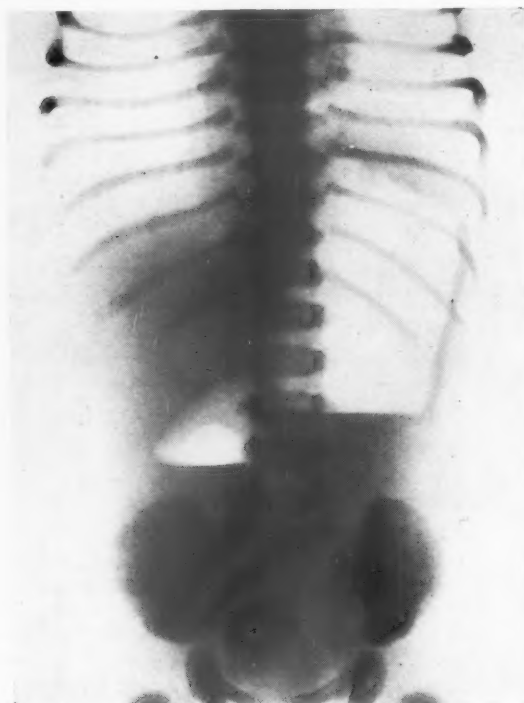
Case 1: radiograph of abdomen (patient sitting up). There are large air bubbles in the stomach and first part of the duodenum, but no air in the rest of the intestine.
